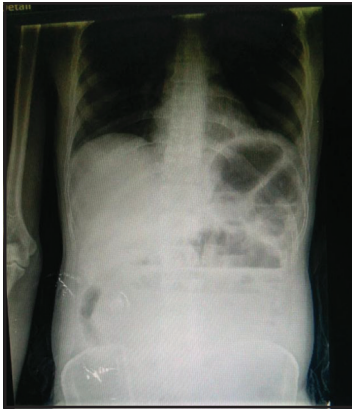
Plain radiograph of the abdomen (standing).
